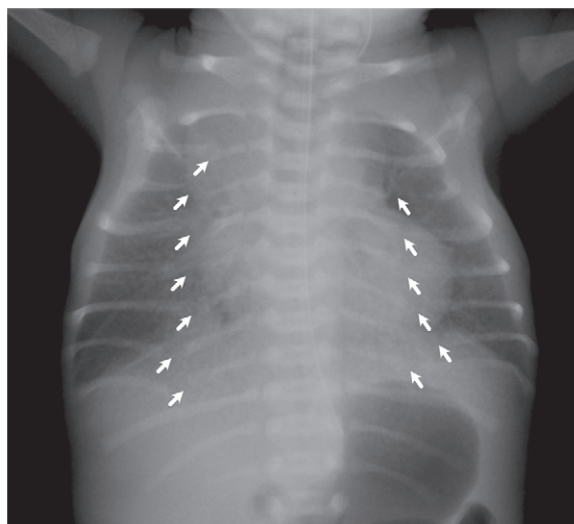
Rib gaps in a neonate with cerebro-costo-mandibular syndrome. Frontal chest radiograph shows multiple posterior bilateral rib gaps (arrows).
